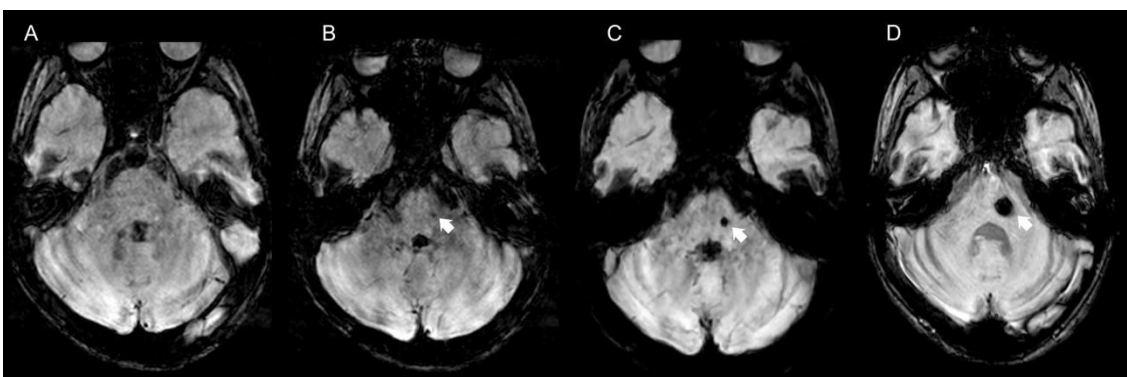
Longitudinal brain MRI including axial magnitude SWI images (A-D) at the same level, performed in a child with familial cerebral cavernous malformation syndrome due to a proven pathogenic variant in the *CCM1* gene demonstrates *de novo* appearance and progressive growth over time of a cerebral cavernous malformation in the left hemisphere (*thick white arrows*).
